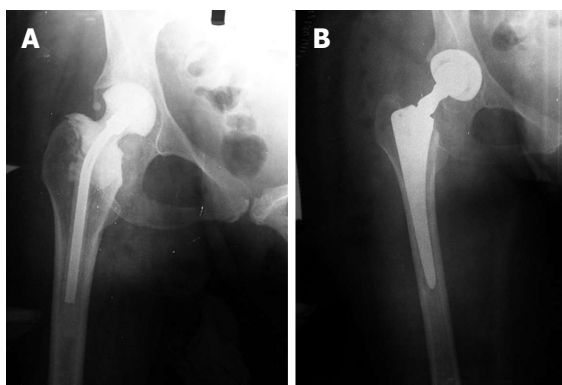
Anteroposterior radiograph of bone loss. A: Anteroposterior (AP) radiograph of the right hip showing minimal bone loss of the proximal metaphyseal bone secondary to periprosthetic hip infection. A antibiotic cement spacer was implanted after irrigation and debridement during the first stage of a two-stage exchange arthroplasty; B: AP radiograph of the same hip after the second stage. The metaphyseal bone loss was minimal and a cementless primary stems with common length and geometry was used.
